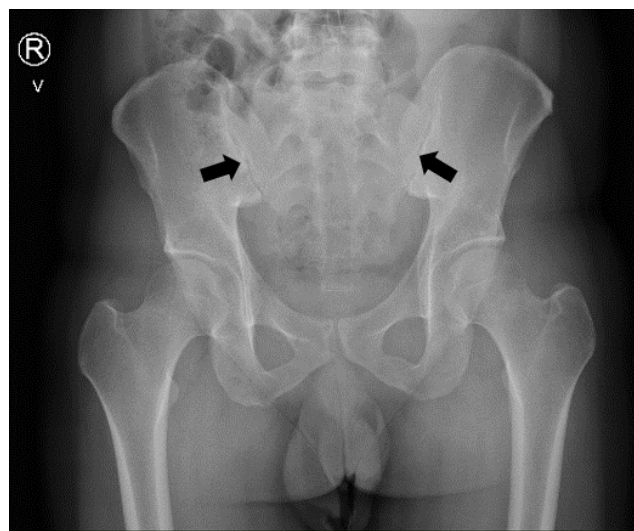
Anteroposterior pelvic X-ray examination.
